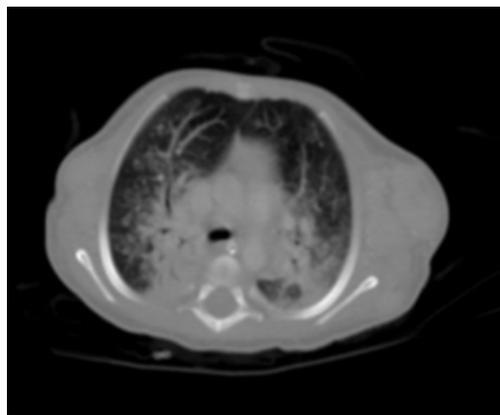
Chest CT scan showed consolidation of the posterior segment of the right and left upper lobe. There is patchy ground-glass opacification with Multiple nodular opacities in both upper lobes more on the right side .also, it showed multiple enlarged axillary lymph nodes.
